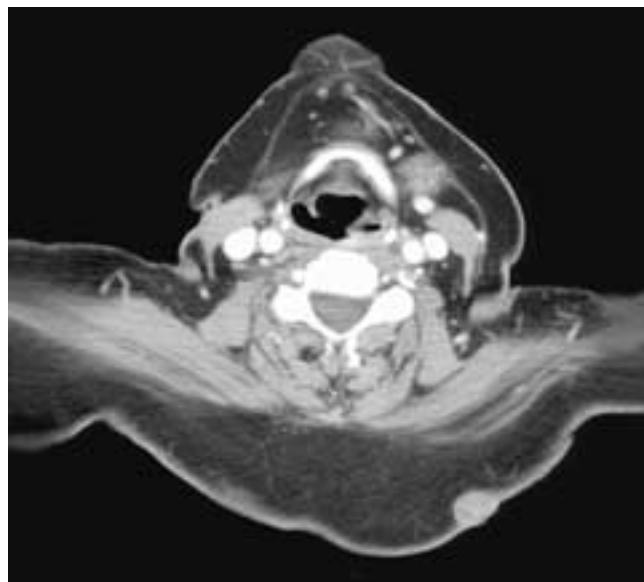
Axial contrast-enhanced CT scan shows a mass in the skin line of the left posterior neck. The deep margin is unsharp in some areas. This patient had a basal cell carcinoma.
